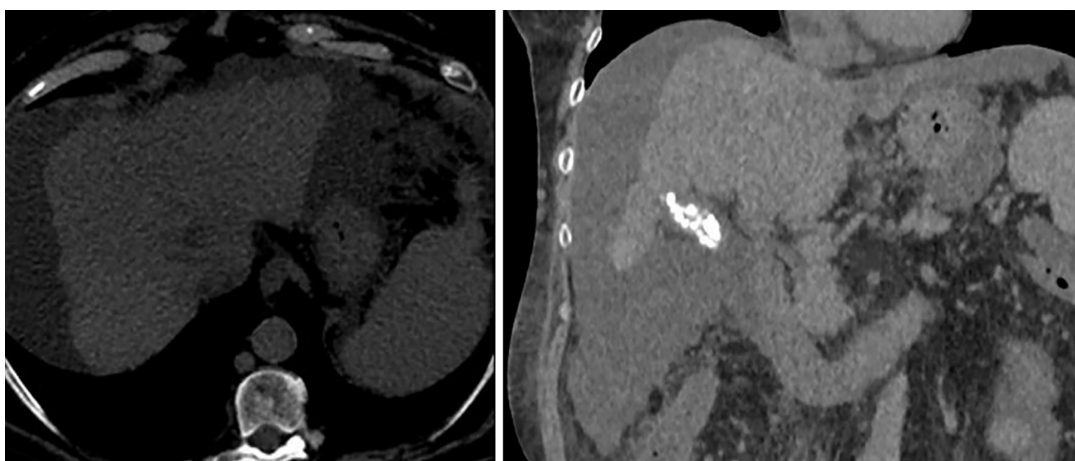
Non-contrast computed tomography scan axial view showing persistence of the heterogeneous lesion in the segment VIII seen previously, not delimitable in the current study. Hypodensity persists in the inferior vena cava and right atrium suggestive of tumor extension, with apparent small reduction, although the intravascular tumor thrombus cannot be properly determined in a non-contrast computed tomography.
